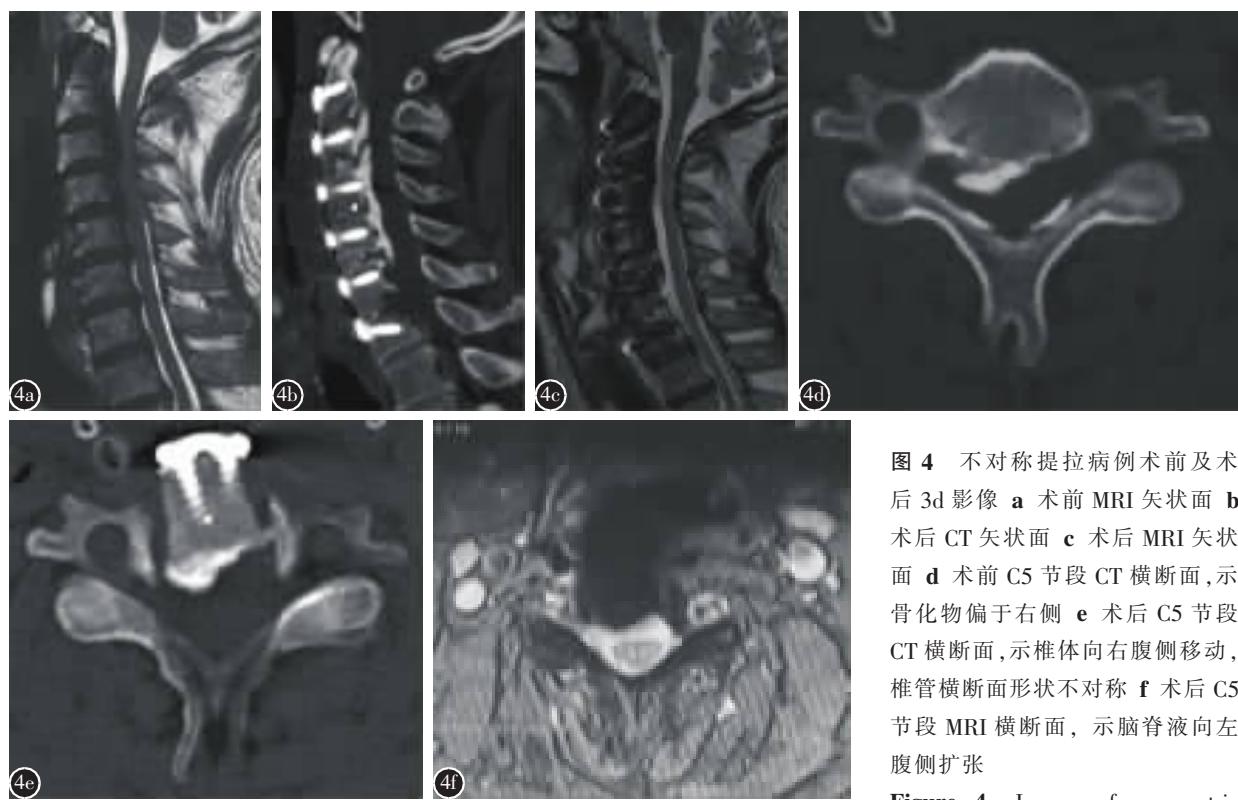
不对称提拉病例术前及术后 3d 影像 a 术前 MRI 矢状面 b 术后 CT 矢状面 c 术后 MRI 矢状面 d 术前 C5 节段 CT 横断面,示骨化物偏于右侧 e 术后 C5 节段 CT 横断面,示椎体向右腹侧移动,椎管横断面形状不对称 f 术后 C5 节段 MRI 横断面,示脑脊液向左腹侧扩张
